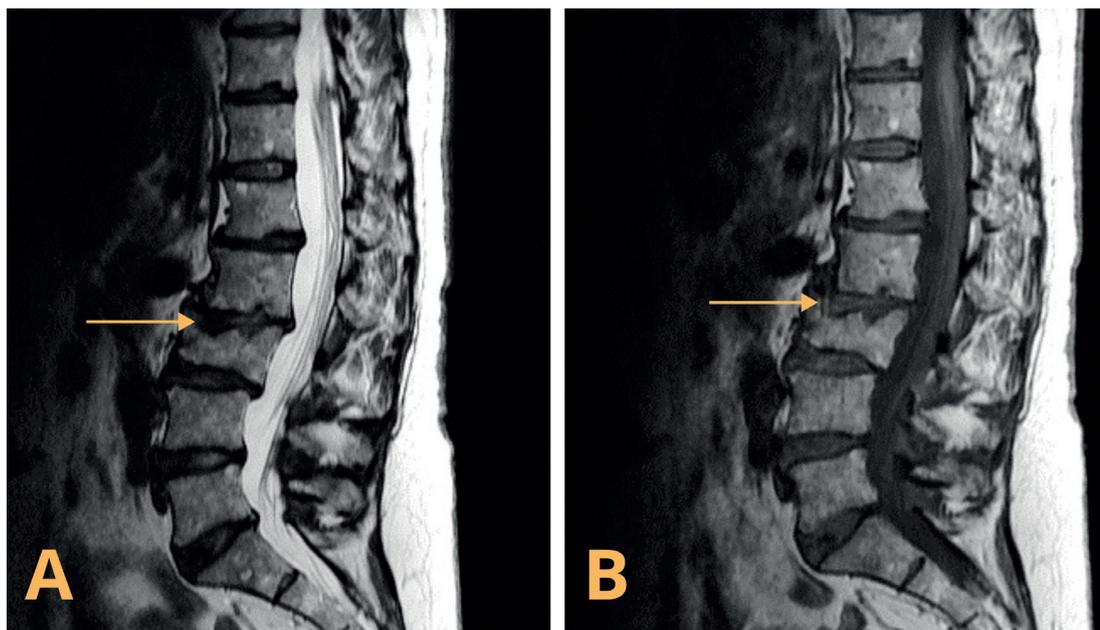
Sagittal T2-weighted (A) and T1-weighted (B) magnetic resonance (MR) images of the lumbar spine in a patient with low back pain. The adjacent endplates of the L2 and L3 vertebral bodies exhibit markedly irregular outlines with preserved cortical bone and degenerative hypointensity of the L2/L3 intervertebral disc on a T2-weighted image. This appearance is consistent with erosive intervertebral osteochondrosis (degeneration of the vertebral endplates)
